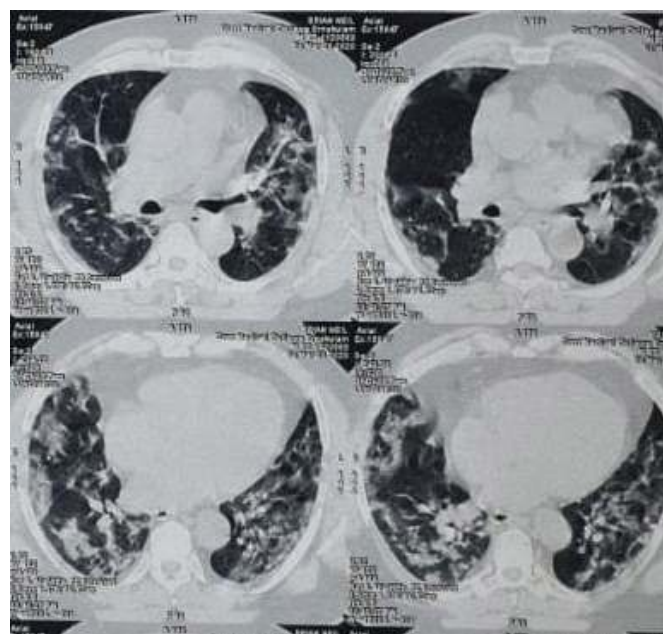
CT Thorax films
